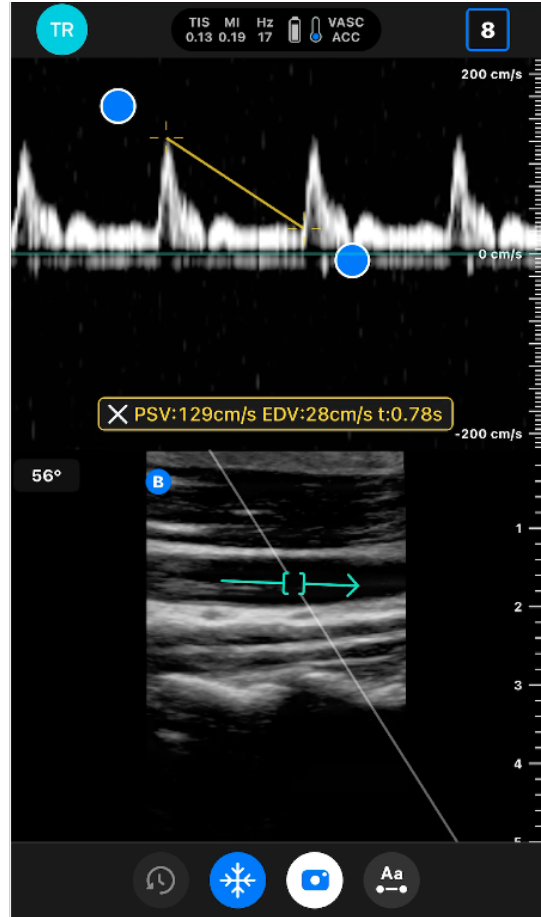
Pre-FDA submission side-by-side comparison with predicate device. On-screen image pairs are shown between the ultrasound-on-chip device (left) and a corresponding scan using a Lumify device (right). Each device is configured to operate in 3 imaging modes:
